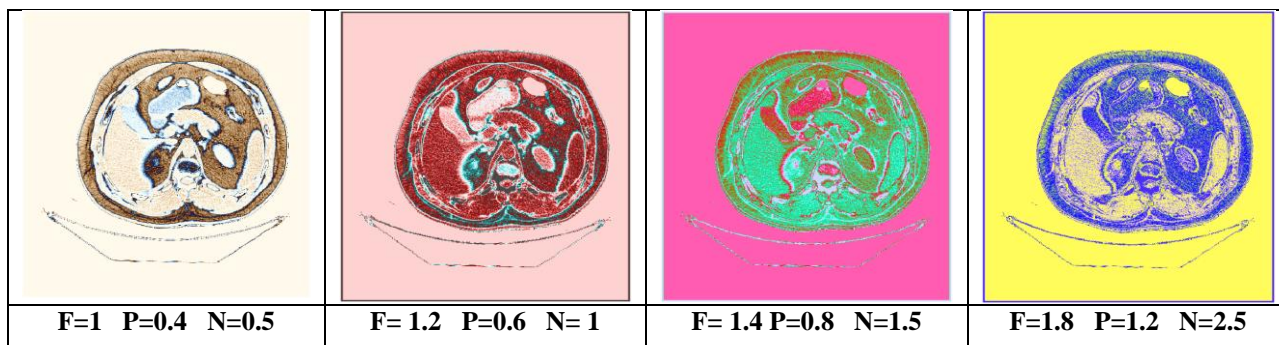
The color output CT Scan images with different F, P, and N values
